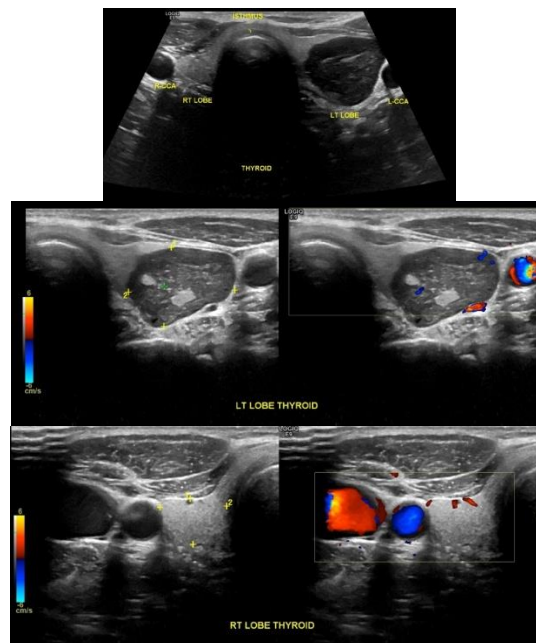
Neck ultrasonography showing the right and left thyroid lobes. The parathyroid gland was not visualized
